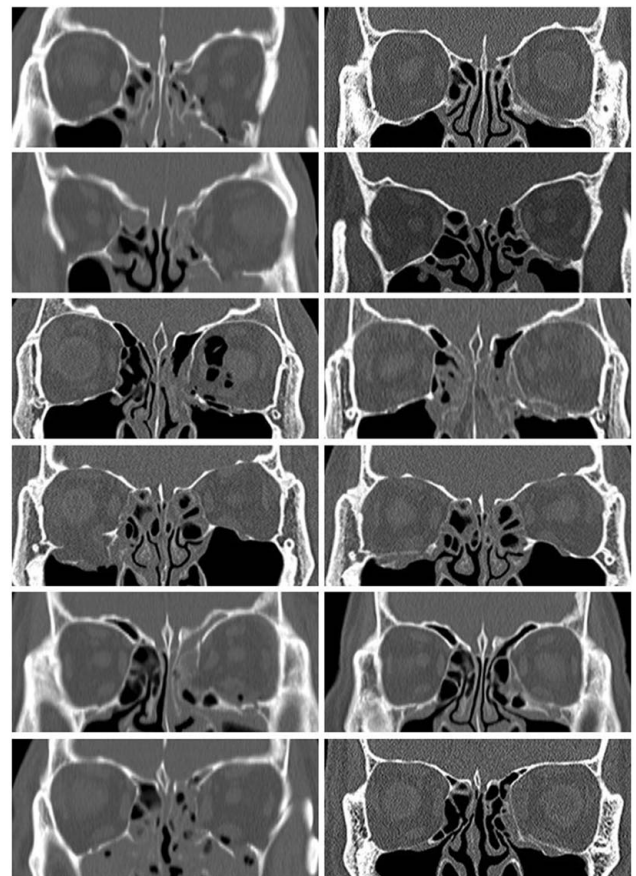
Preoperative and postoperative computed tomography (CT). After examining the coronal CT scans obtained after surgery from patients with inferomedial orbital wall fractures who received 3D-printed implants customized for them.
